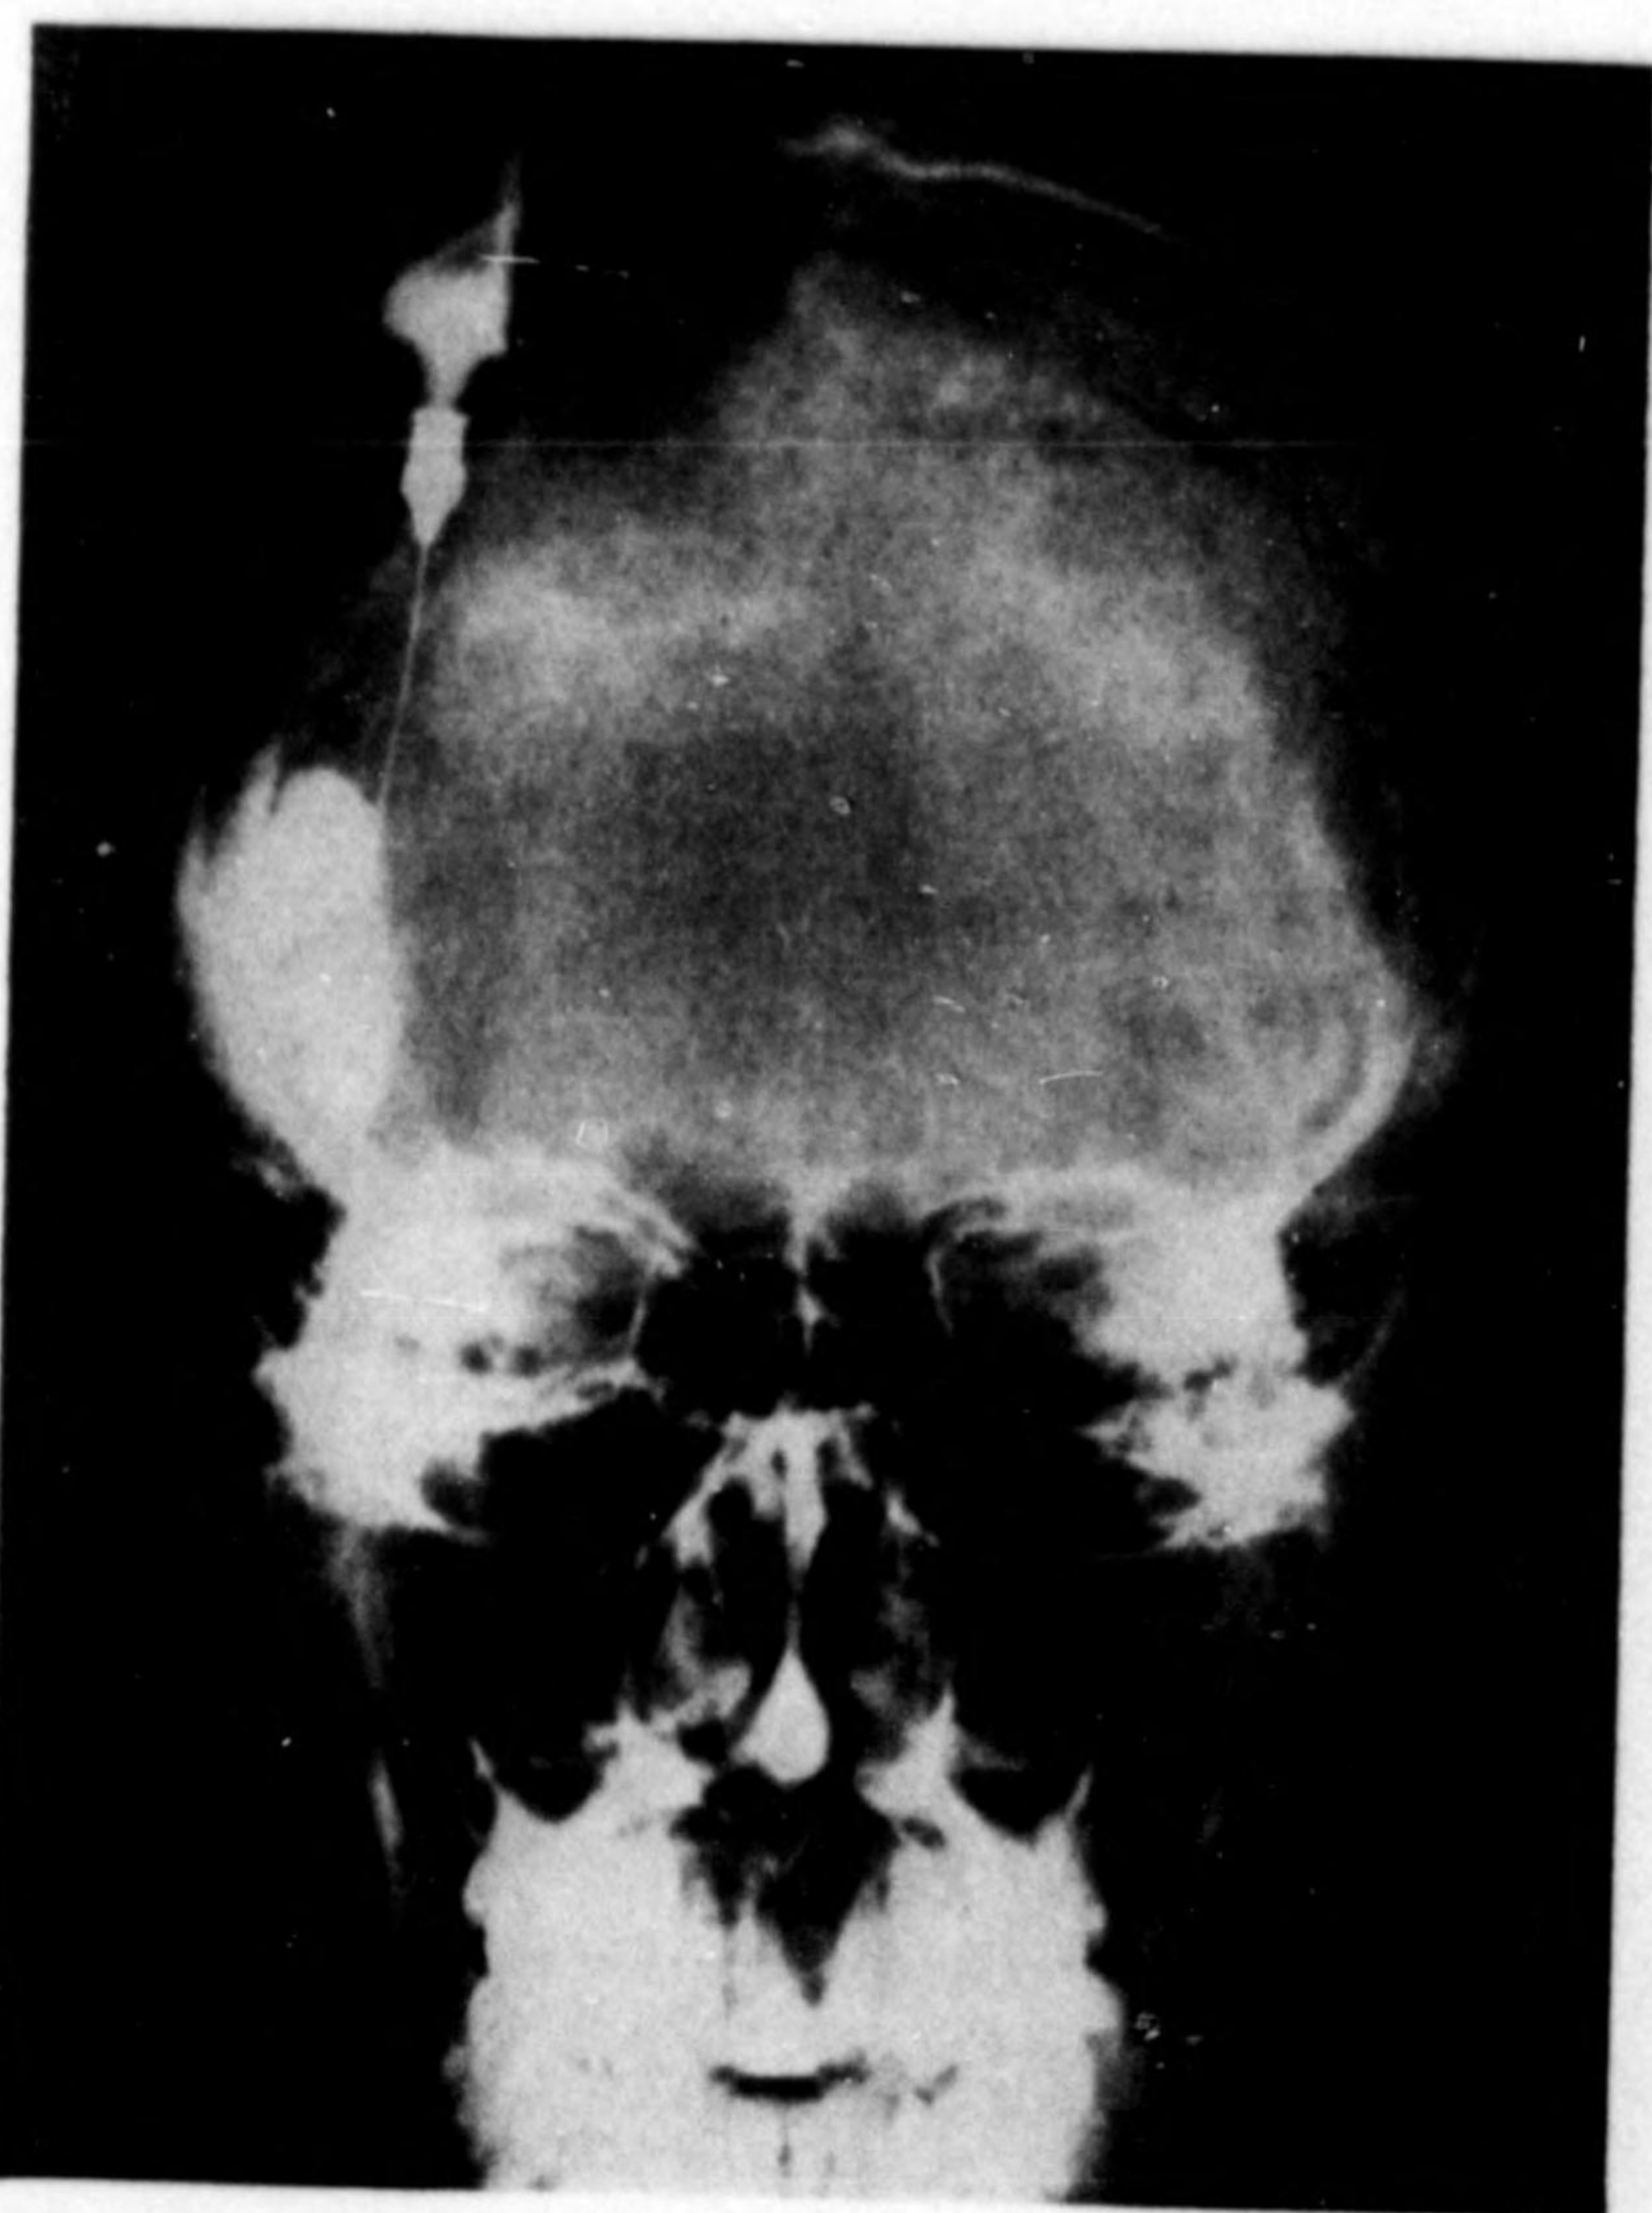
Radiograph of the skull in the postero-anterior position showing location and character of the lesion after injection with thorotrast.
